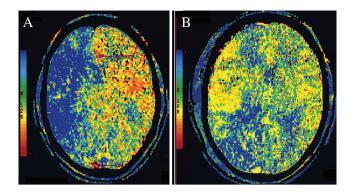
Single-photon emission computed tomography (SPECT) scan revealed a perfusion defect in the right frontal (hypoperfusion) and decreased cerebrovascular reactivity in the right hemisphere on the pre-operative with acetazolamide challenge test.
